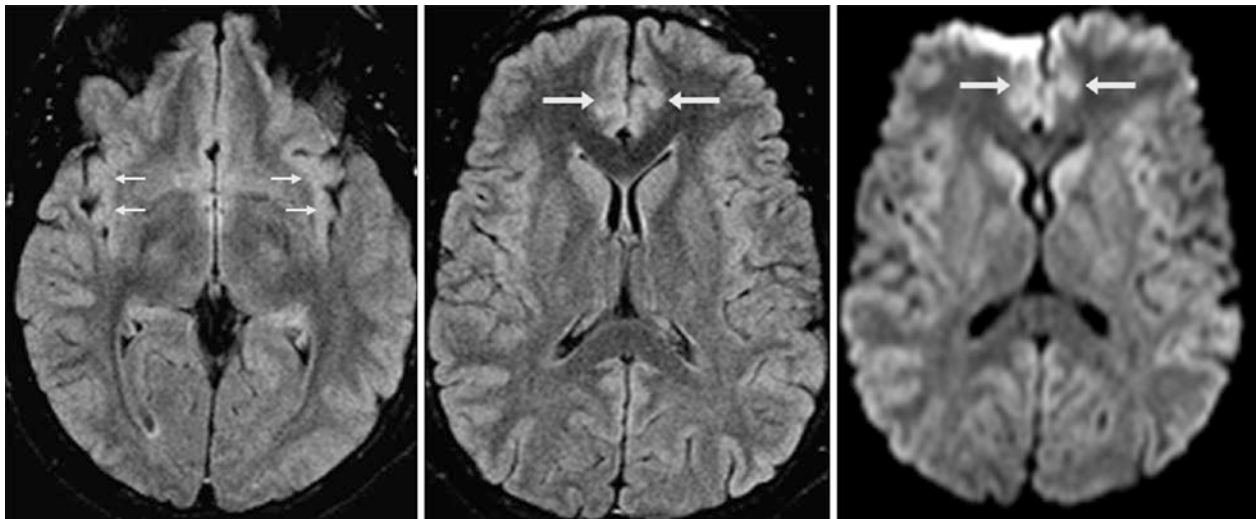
A 24-year-old with headaches had a 1.5 T MRI that depicts mild, diffusely hyperintense cingulate (*arrows*) and insular (*thin arrows*) cortices on FLAIR (*left and middle*) and DWI (*right*). This case
